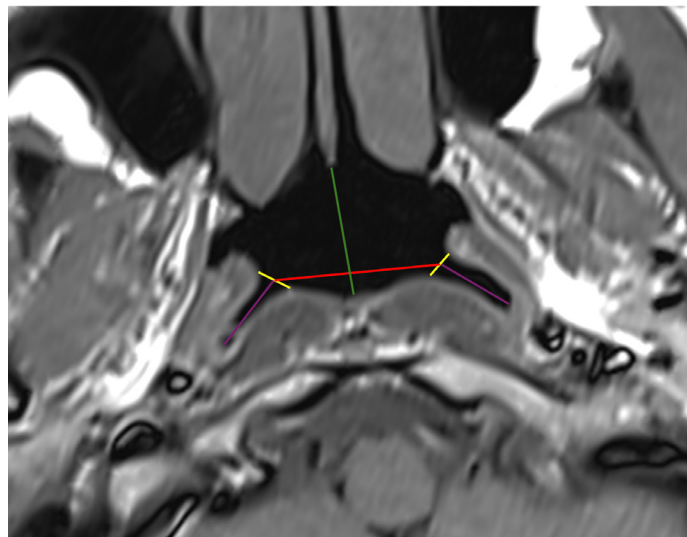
T1-weighted FSE MR image depicting morphometric measurements of the Rosenmüller Fossa (RF) and its anatomical relationship with surrounding structures. Yellow lines indicate the bilateral openings of the RF. Purple lines represent the depth of the RF on both sides. The red line measures the transverse distance between the right and left RF. The green line shows the linear distance between the posterior nasal spine (PNS) and posterior pharyngeal wall, serving as a reference for nasopharyngeal depth
